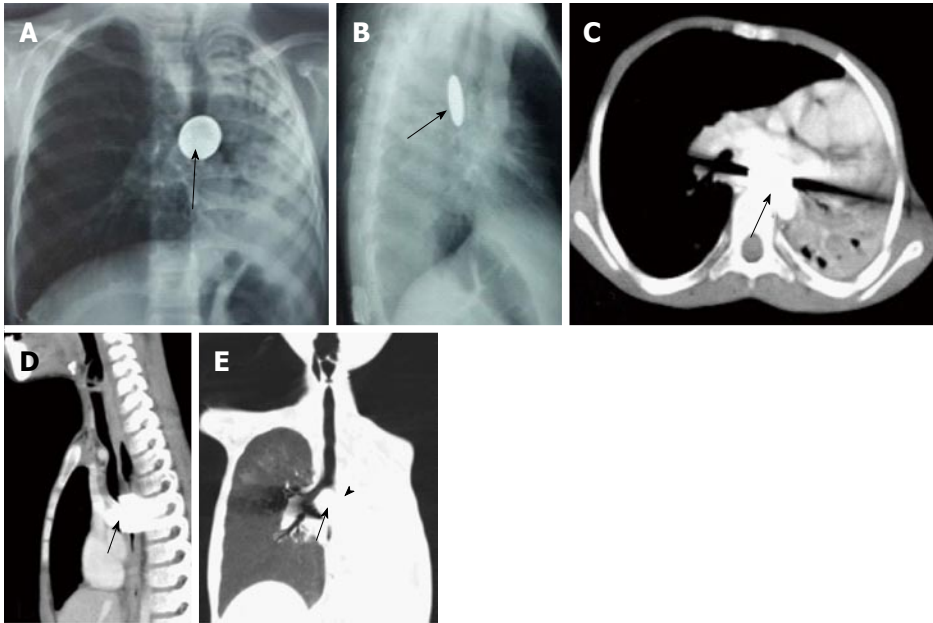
Impacted esophageal foreign body compressing airway. Frontal (A) and lateral (B) radiographs of chest reveal a well-defined round radio-opaque foreign body in the esophagus at the level of carina (arrows) with associated volume loss of left lung. Contrast enhanced axial (C) and sagittal (D) MPR images show a hyperdense foreign body giving streak artefacts impacted within the esophagus (arrow). Coronal MinIP image (E) shows near complete occlusion of left main bronchus (arrowhead) by the impacted esophageal foreign body (arrow) with collapse of left lung. MPR: Multiplanar reformation; MinIP: Minimum intensity projection.
